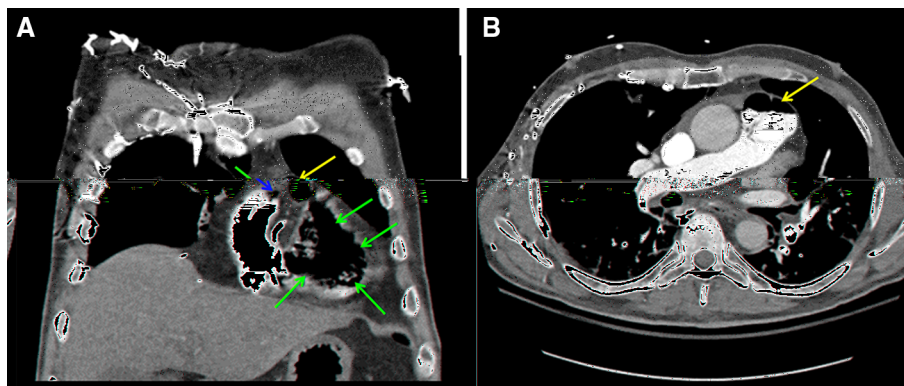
Figure Coronal (A) and axial (B) contrast-enhanced computed tomography of the chest shows a massive venous air embolism (VAE) in the right atrium (green arrow), right ventricle (red arrows), and main pulmonary artery (yellow arrows). In addition to being present in the non-dependent locations of the right heart and pulmonary artery, air was also noted to track intravenously from
